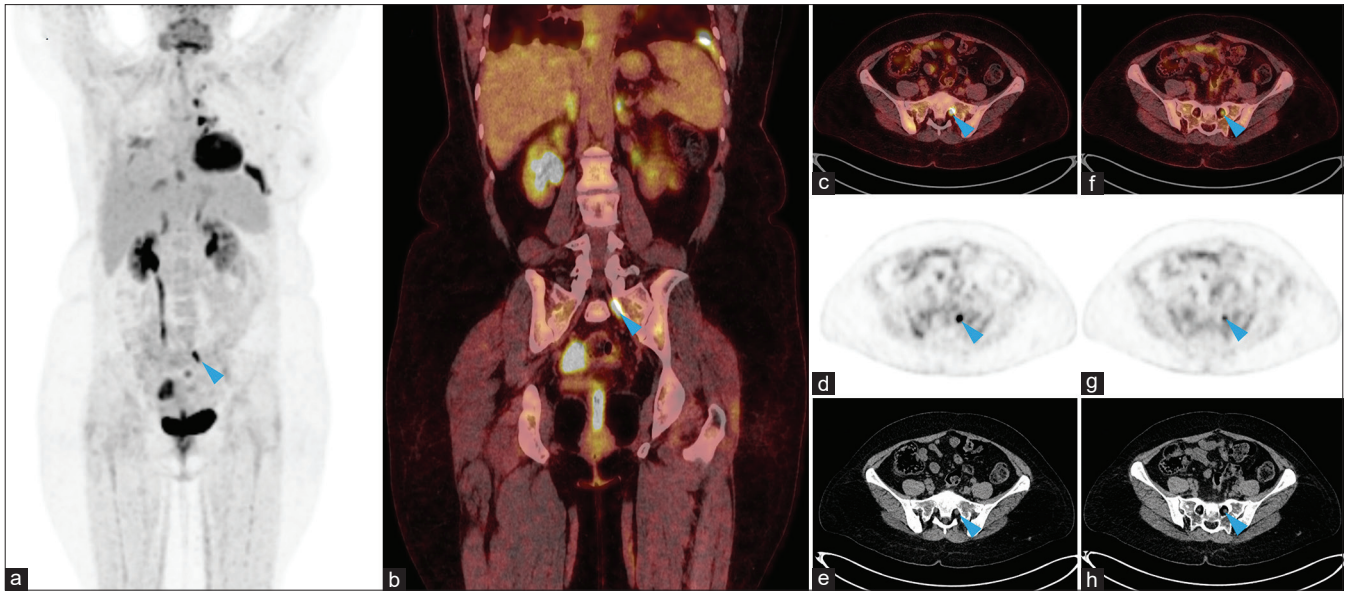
FDG PET/CT scan of a woman with history of breast cancer reveals multiple metastases along with a segmental increased FDG uptake along the asymmetrically thicker left first sacral nerve root (a-h, arrowhead), consistent with nerve root metastasis
